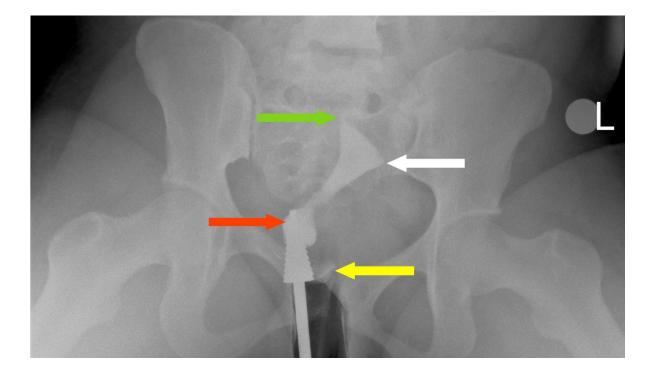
A frontal radiograph of a hysterosalpingography showing pooling of contrast medium around the cervical canula suggestive of a patulous cervix as indicated by the red arrow, back flow of contrast (yellow arrow), right tubal blockage (green arrow), and left tubal blockage (white arrow).
